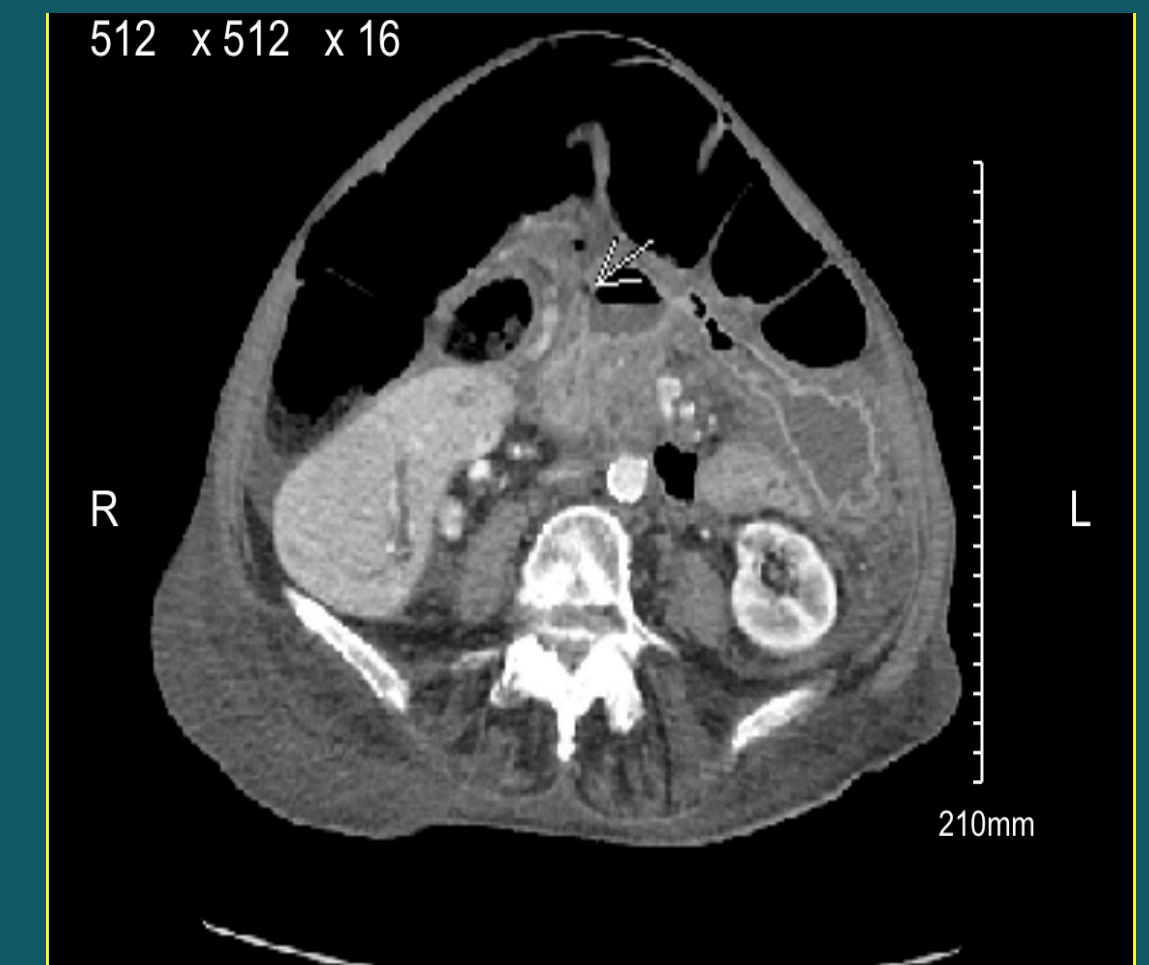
CT abdomen pelvis with contrast showing pneumoperitoneum with focal defect in stomach
